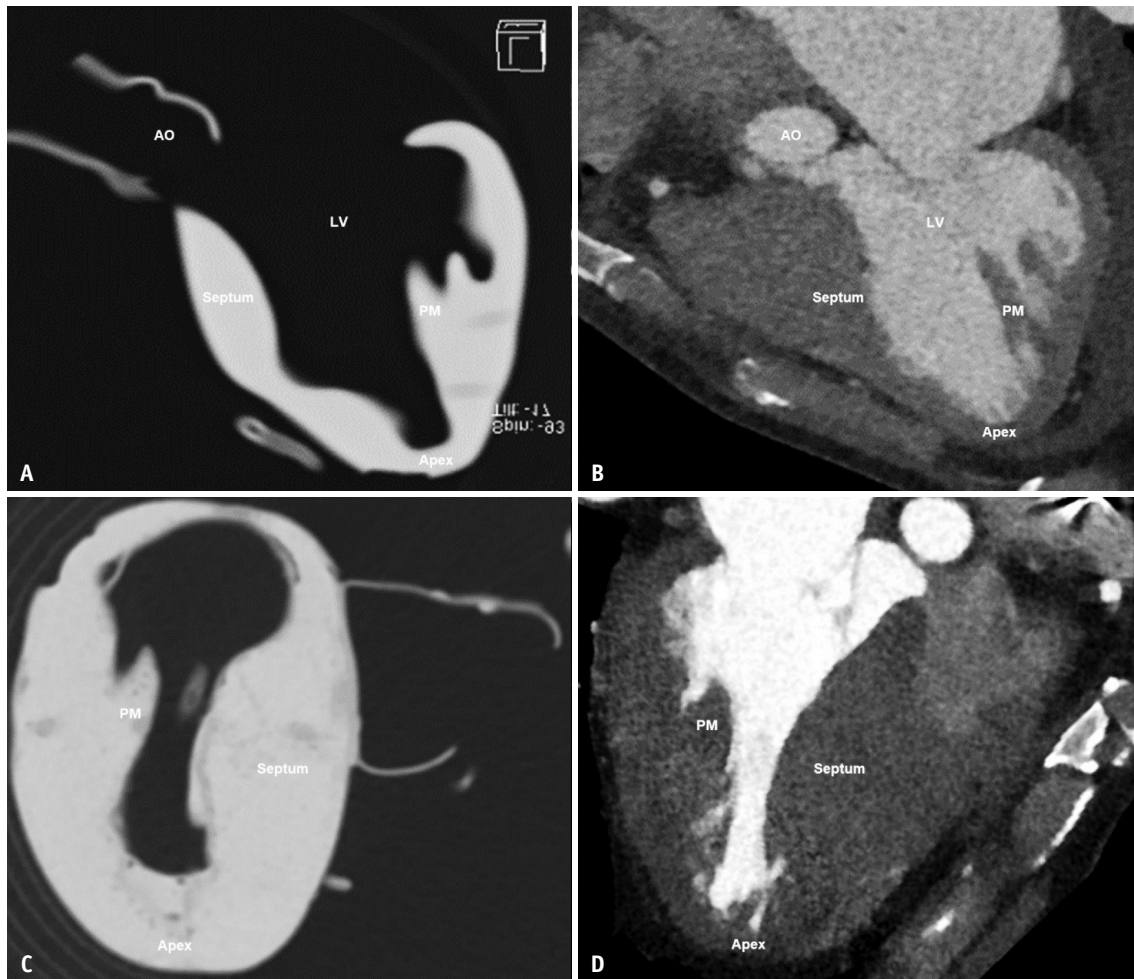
Representative CT images obtained from the myocardial model (A, C) verify the structural consistency of the myocardial model compared with that of the cardiac CT images (B, D) of patient 2 and patient 3. However, the apical segments and the apex of the myocardial model of patient 3 were relatively thicker than those shown by cardiac CT (C). AO = aorta, LV = left ventricle, PM = papillary muscle
